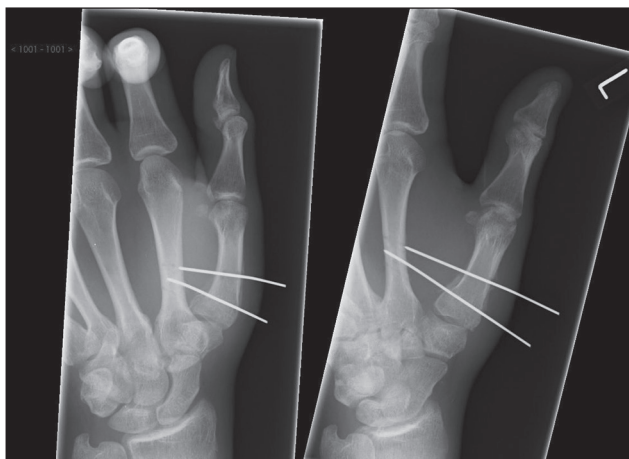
Radiograph demonstrating anterior-posterior and oblique views post K-wire fixation
